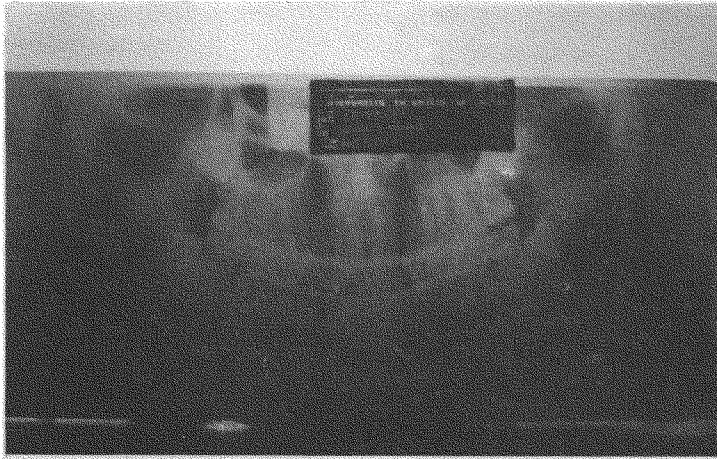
The post-op x-ray show the fragment were reduced and fixed into the normal anatomical position.
